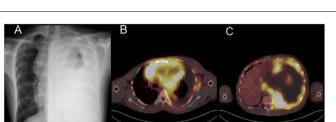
(A) Chest X-ray image showing unilateral white hemithorax associated with massive pleural effusion causing contralateral displacement and an anterior mediastinal mass. (B, C) PET-CT: Large heterogeneous lymph node cluster in prevascular mediastinal fatty space, with areas of hypometabolism and necrosis and other hypermetabolic regions consistent with malignancy, displacing mediastinal structures to the right and engulfing the large vessels. Significant for marked left pleuropulmonary thickening, measuring up to 6 cm in the paracardiac region, with intense pathological metabolic activity.
